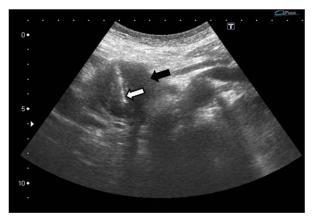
Transverse sonogram shows a 4-cm hypoechoic mass (black arrow) in the head of the pancreas. Post-firing sonogram shows the echogenic needle in the mass (white arrow). Pathology confirmed an adenocarcinoma.
